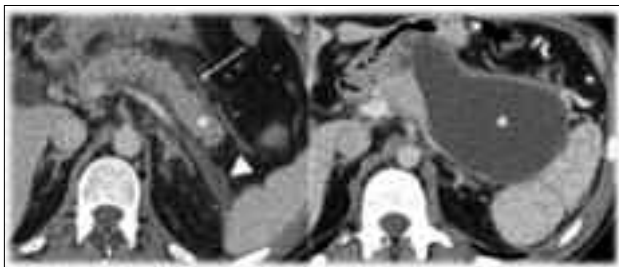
Interstitial oedematous pancreatitis. A – axial contrast-enhanced CT in venous phase, shows enlarged, heterogeneously enhanced gland (*), with indistinct margins and some stranding and minimal fluid (arrow) in the peripancreatic fat; acute peripancreatic fluid collection in the anterior pararenal space (arrowhead) is also present. B – five weeks later, the collection becomes more organised with capsule and is termed pseudocyst
